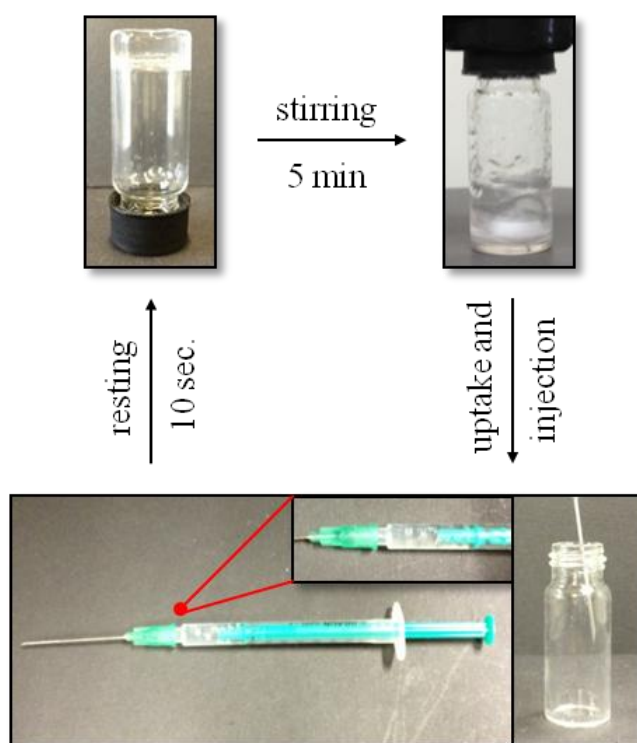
Digital photographs demonstrating the thixotropic and injectable nature of gels from 1 in toluene (17 mg/mL) prepared by the ultrasonication enhanced gelation protocol. Vigorous stirring of the gel for 5 min results in the formation of a viscous solution, which can be uptaken using a syringe (1 mL volume) and injected into a vial afterwards, resulting in reformation of a stable gel within 10 sec.
